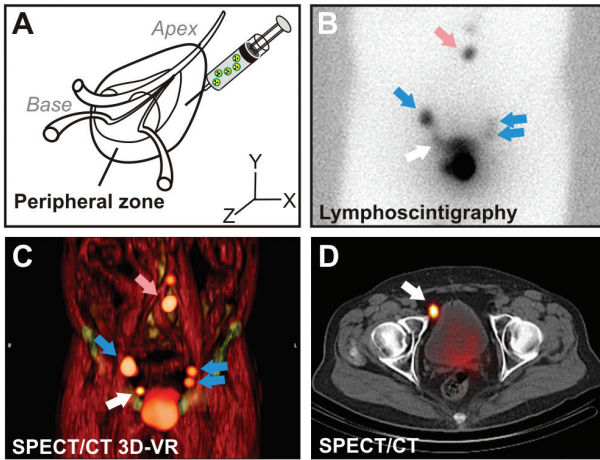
Preoperative Sentinel node mapping. After tracer injection in the peripheral zone of prostate (A), planar lymphoscintigraphic images are acquired to identify the SNs (B). SPECT/CT imaging allows identification of the anatomic location of the SNs and, in some cases, identification of SNs outside extended pelvic lymphadenectomy field; here, a paravesical SN (white arrow) not clearly detectable on the lymphoscintigraphic image was identified after SPECT/CT imaging (C-D). In this patient, five SNs were detected, with two being located outside extended pelvic lymphadenectomy field (white and pink arrows). SN = sentinel node; SPECT/CT = single photon emission computed tomography combined with computed tomography; 3D-VR = three-dimensional volume rendering.
